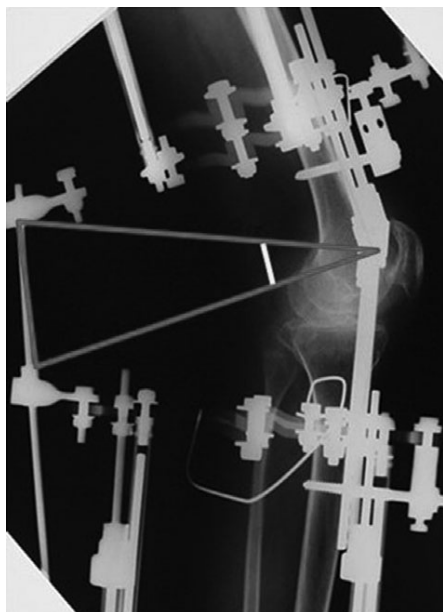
Placement of the hinges of the Ilizarov frame are shown on this lateral X-ray. The rate of distraction is calculated according to the equilateral triangular rule (triangle in red, neurovascular structures at risk is shown in yellow, which is the sciatic nerve).
